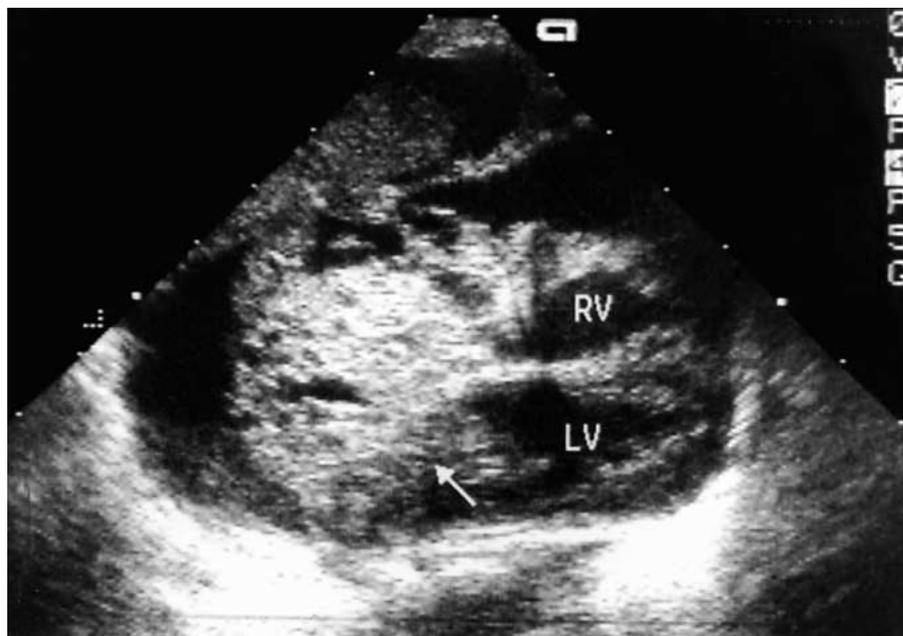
Echocardiographic subxiphoidal four-chamber view immediately after birth. The heart is surrounded by pericardial effusion. The tumor (arrow) arises from the atria and reaches the atrioventricular level (RV = right ventricle, LV = left ventricle).
